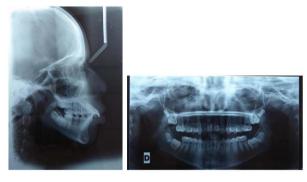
Pre-treatment lateral cephalogram and panoramique radiograph.
